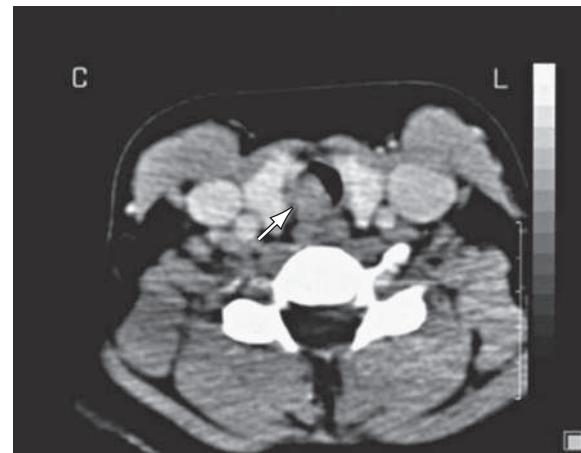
CT scan of the trachea with a circumscribed intraluminal tracheal mass (arrow) in the tracheal wall. (From Venizelos I, Papathomas T, Anagnostou E, et al. Pediatric inflammatory myofibroblastic tumor of the trachea: a case report and review of the literature. *Pediatr Pulmonol*. 2008;43:831–835.)
